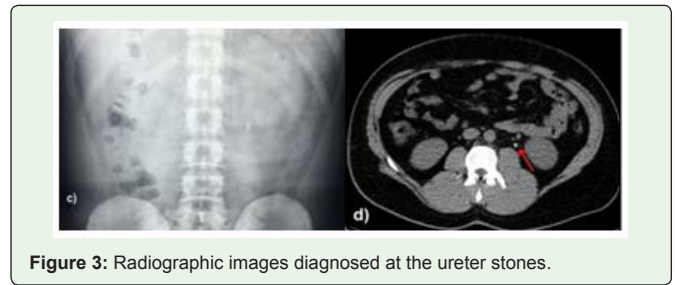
Radiographic images diagnosed at the ureter stones.
